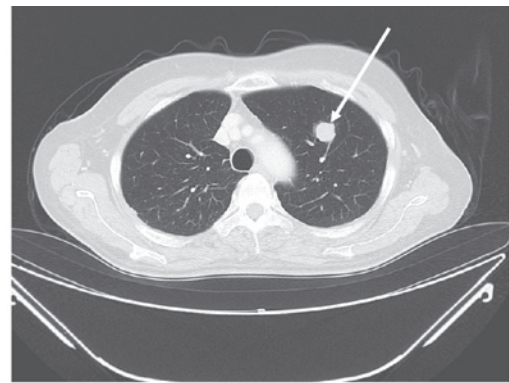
Contrast-enhanced computed tomography of the lungs showing a metastatic lesion (arrow).
